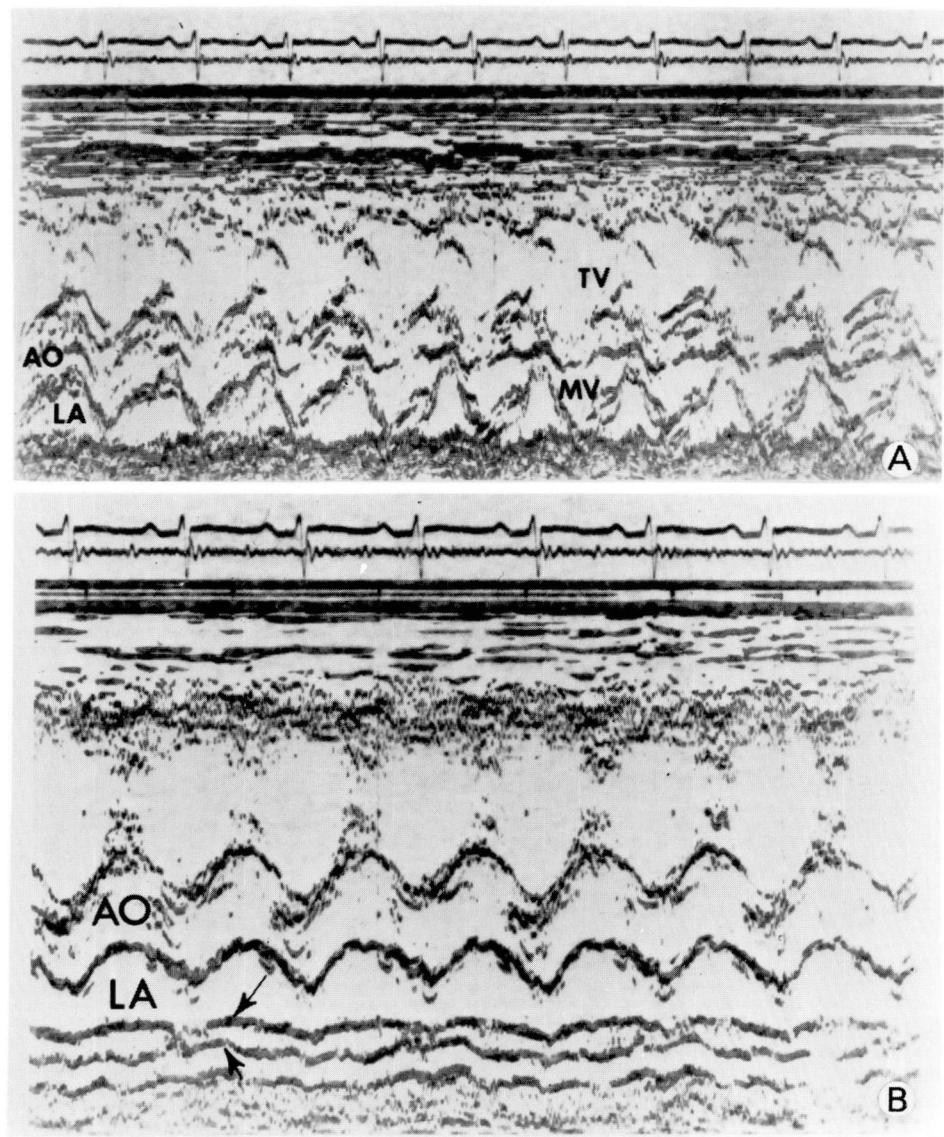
M-mode echocardiogram demonstrating a scan from the mitral valve to the aorta, again showing the marked enlargement of the right ventricle with compression of the mitral valve and left ventricle. On scan to the aorta, the left atrium appears small. AO = aorta, LA = left atrium, and other abbreviations as in *Figure 1*. B. M-mode echocardiogram showing normal left atrial and aortic dimensions. Arrows point to a linear structure posterior to the left atrium, which is the common pulmonary venous chamber that drained to the coronary sinus.
